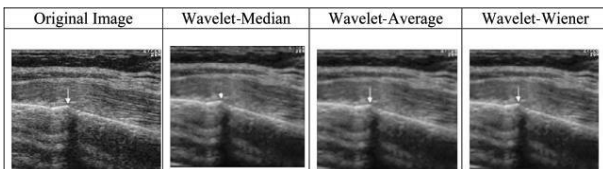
Rib fracture ultrasound image, sample 2.
